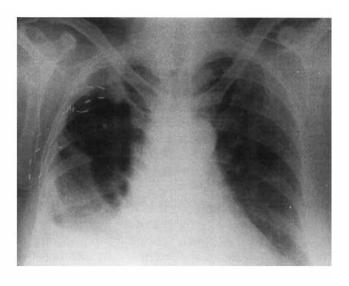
Chest radiograph after 2 weeks of intracavitary Depo-Medrol therapy, showing significant reduction in fluid. Film was taken before drainage and additional Depo-Medrol injection.
